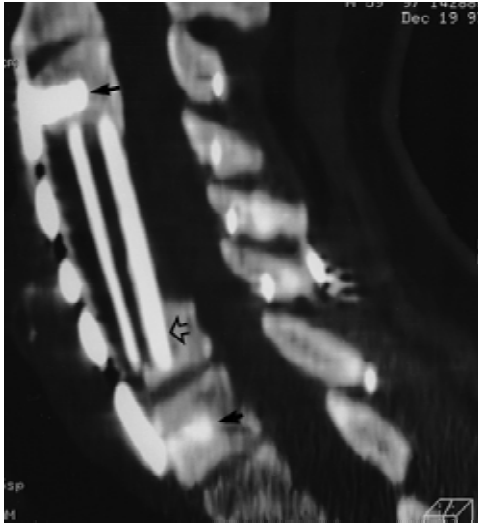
Lateral two-dimensional midline sagittal CT scans obtained 1.5 years after C3–C6 ACF/PWF C3–C7 resulting in vertebral fracture of C6 and subsequent C3–C7 Orion plating (case 1). A 59-year-old man had a nonplated C3–C6 ACF (fibula) with C3–C7 PWF. When the anterior cortex of C6 fractured within 24 hours of surgery, the fragment was removed while the graft was left in place because it was lodged in the C6 body. An Orion plate was added from C3–C7. Eighteen months later, the two-dimensional midline sagittal CT showed adequate localization of the plate (double arrows) and fibula graft (open arrow), whereas other views continued to confirm fusion, which was originally demonstrated 4 months after operation.
